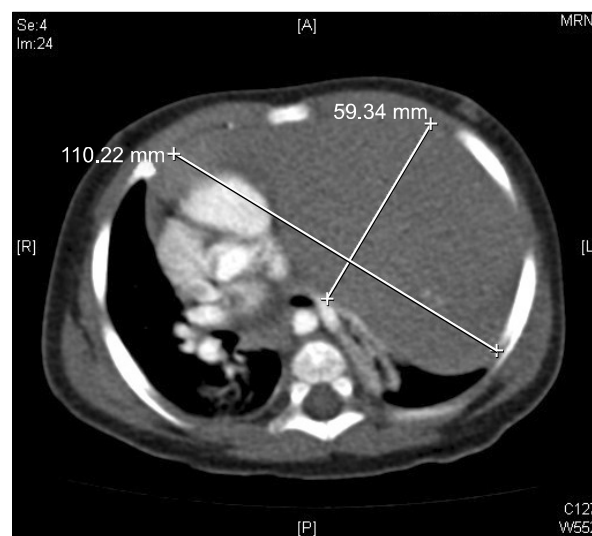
Chest CT scan shows the huge anterior mediastinal mass (11 $\times$ 5.9 cm sized) pressing the heart and the great vessels to right side.
